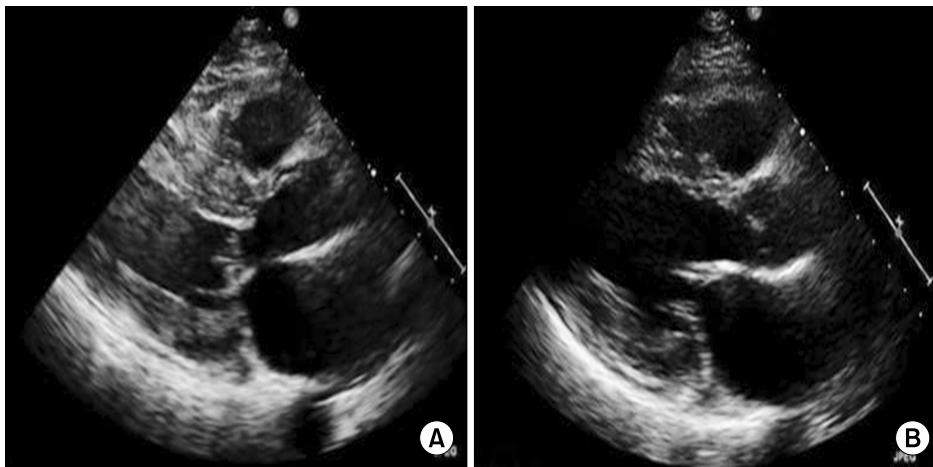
(A) Parasternal long axis view of the patient described in this study, showing left ventricular outflow tract obstruction with systolic anterior motion. (B) Relieved left ventricular outflow tract obstruction with a resected interventricular septum after myectomy.
